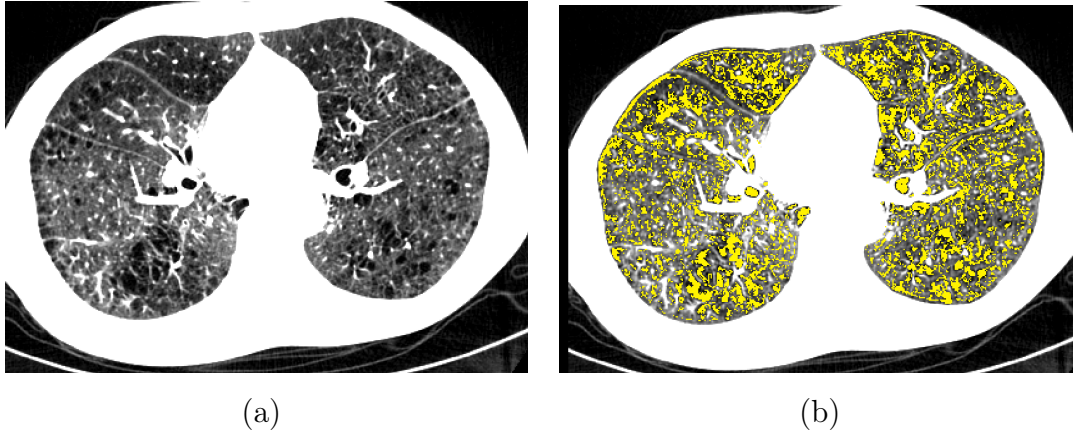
Example of classification results on an axial CT slice, with yellow color indicating regions classified as emphysema (here, the large airways have not been removed prior to the analysis).*
